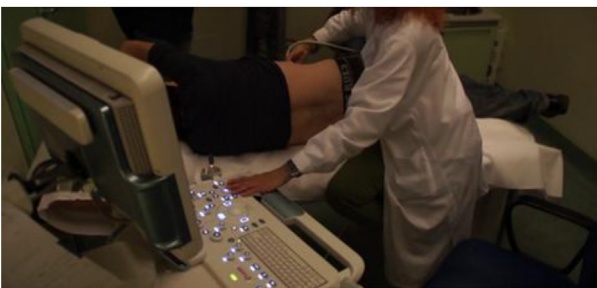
On the left: An example of the spine displacement during an exam performed by a professional sonographer. On the right: an example of a standing posture with the shoulder abducted for a prolonged time without any arm support (single fitting, in column).
